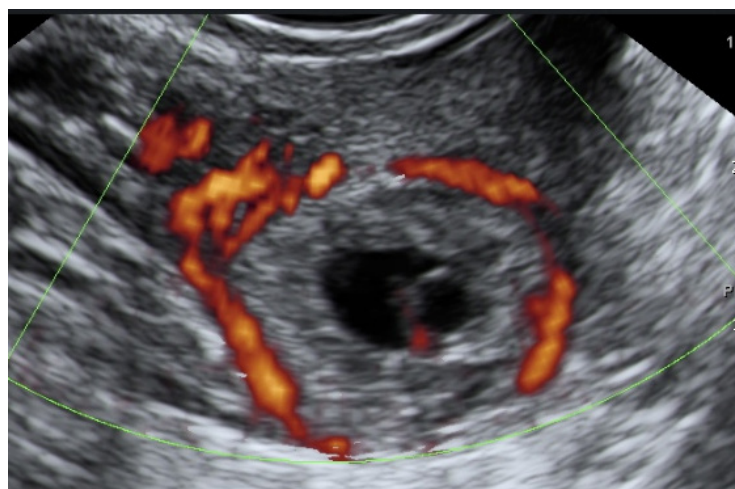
Ultrasound showing an ectopic pregnancy with a gestational sac and a fetal echo in the fallopian tube. There is blood flow around the fallopian tube
